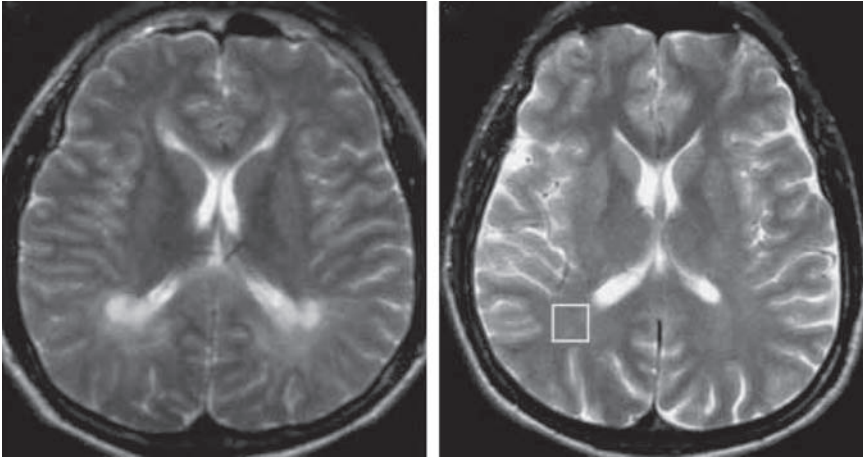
In patients with phenylketonuria (PKU), lesions are visibly most prominent in the periventricular white matter. In these T2-weighted transversal MR images, white matter appears dark. Note the pathological lesions (bright white) in the posterior parts of the lateral ventricles in the patient with PKU (left) when compared to a healthy volunteer (right). From Dezortova et al. (2001). Copyright 2001 by Taylor & Francis. Reprinted by permission.
